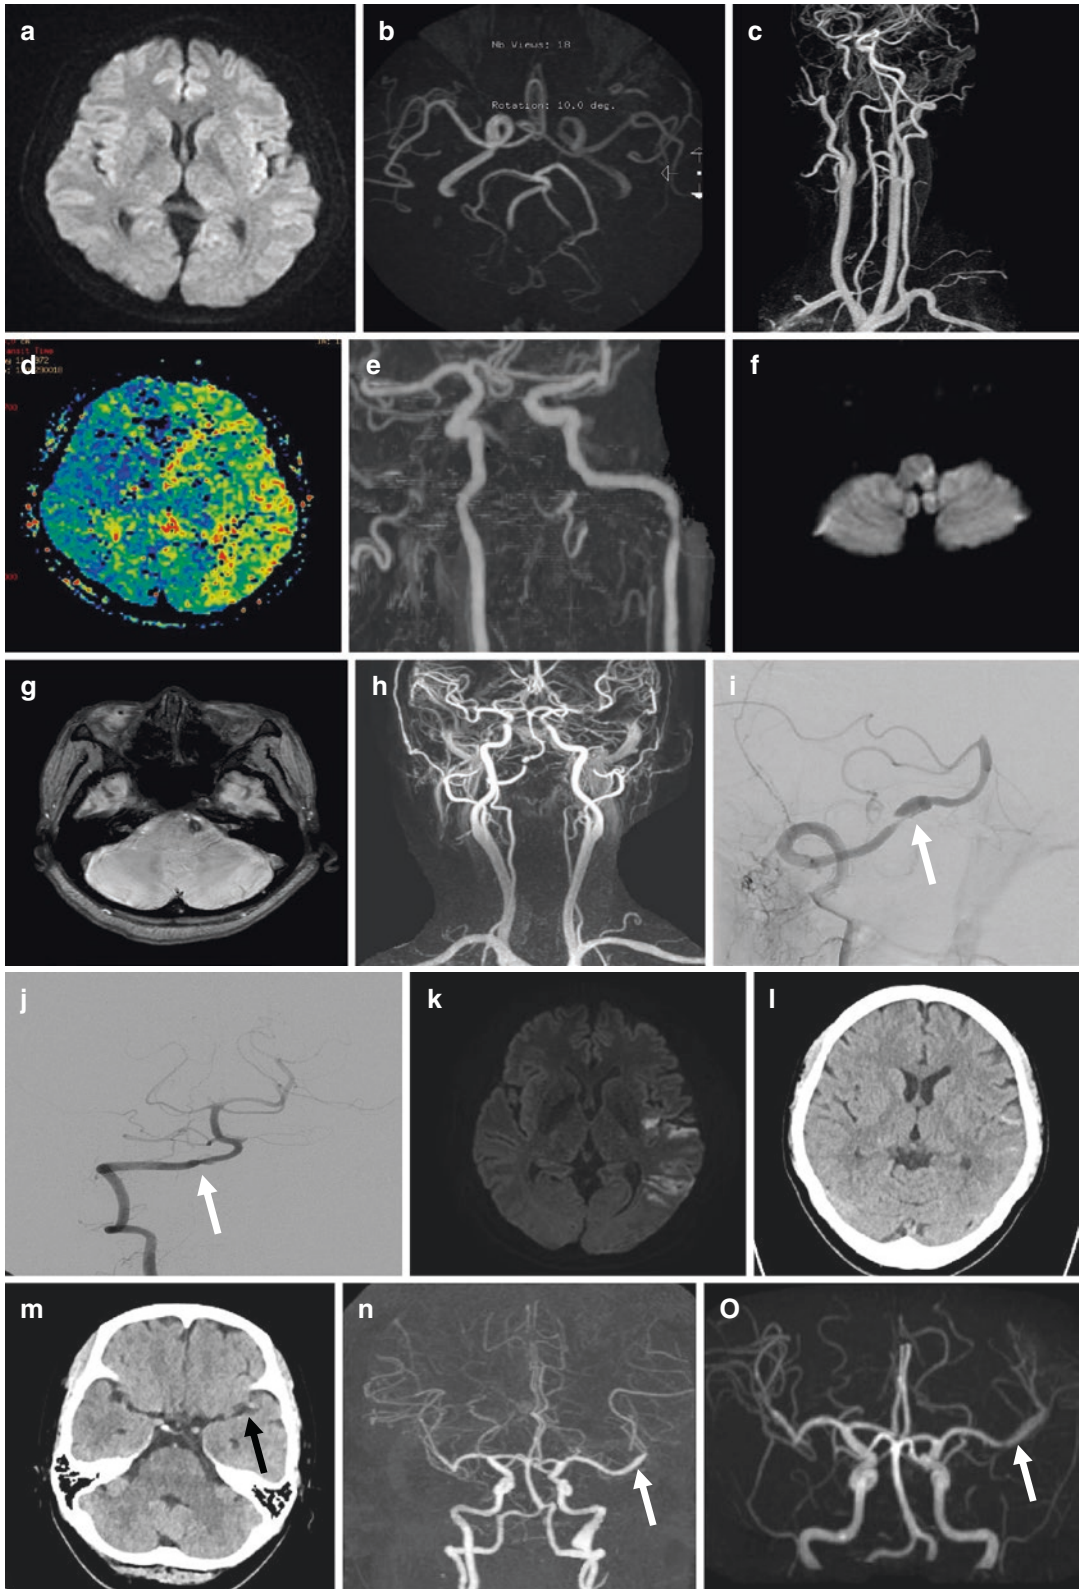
Phenotype of cervical artery dissection. Cerebral artery dissection occurs in various segments of the cervical and intracranial arteries. Images (a–e) indicates a carotid artery dissection. A 45-year-old man experienced a transient right-sided weakness. DWI (a) showed no abnormal lesions, but MRA (b, c) showed a severe stenosis of long segment of the left carotid artery. PWI (d) showed a perfusion delay in the left MCA territory. Follow-up MRA (e) revealed a significant resolution of the dissected carotid artery. Images shows a vertebral artery dissection (f–j). DWI (f) shows a lateral medullary infarction, and SWI shows acute thrombus in the distal
